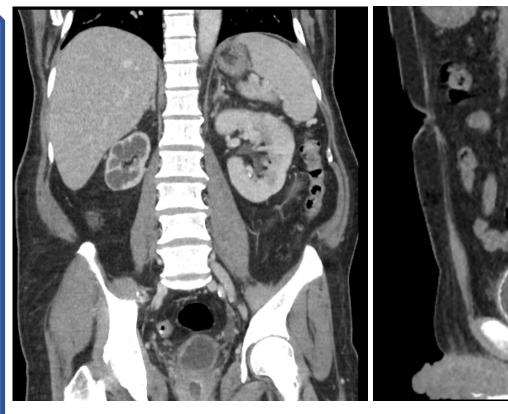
Coronal CT showing atrophic right kidney with cortical thinning and pelvicalyceal dilatation secondary to tuberculosis
